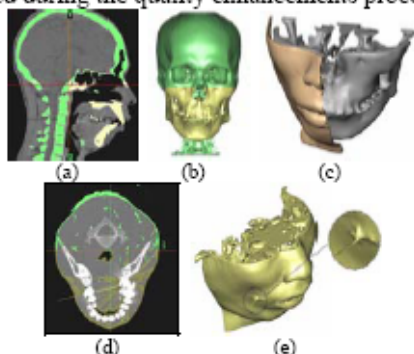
Geometrical data sets. (a): Computer Tomography image slice, (b): Patient specific 3D facial model, (c): Facial model without soft tissue, (d): Bright spots on CT image caused by metal filling in the teeth, (e): Distorted 3D models due to artifact
